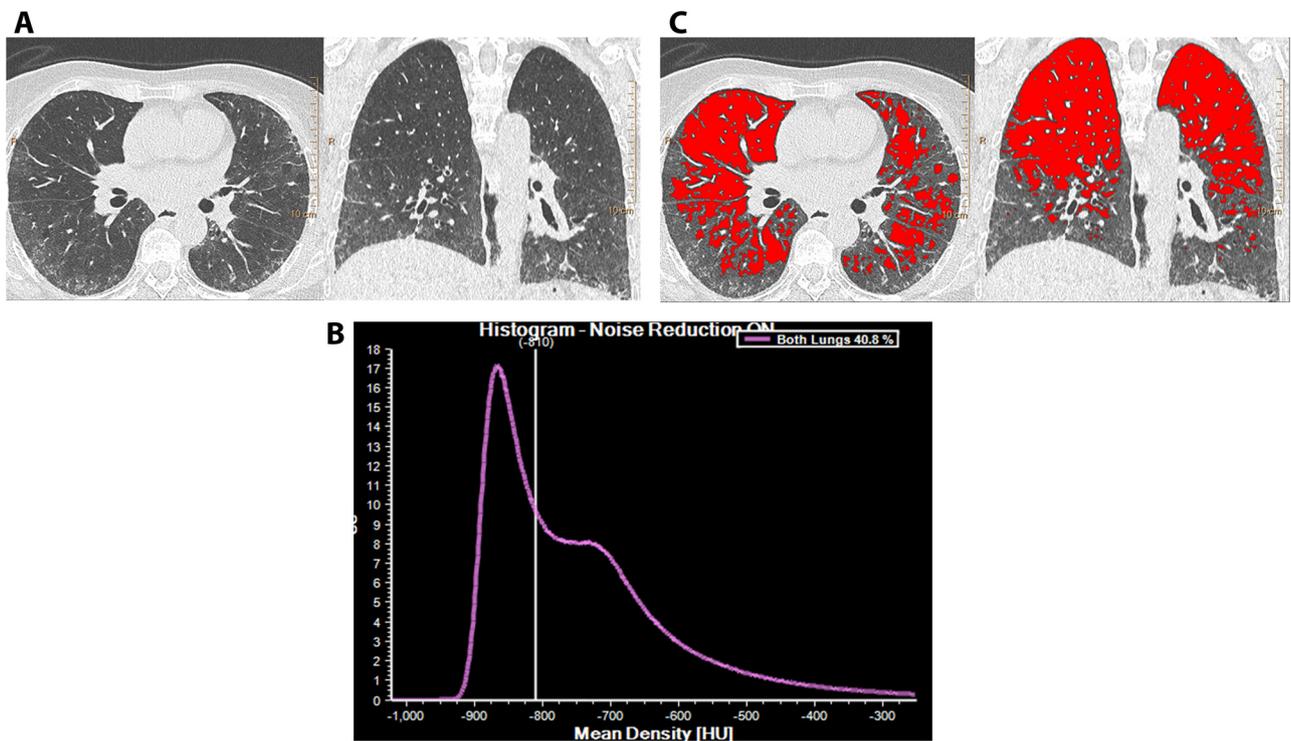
A, B, C: Interstitial lung disease on CT in a systemic sclerosis patient (A) and accompanying histogram with a threshold set at -810 HU (Hounsfield units) (B). Red colour represents all non-ILD affected lung tissue below a threshold of -810 HU; diseased lung is not marked and shows the CT ILD patterns (C).
